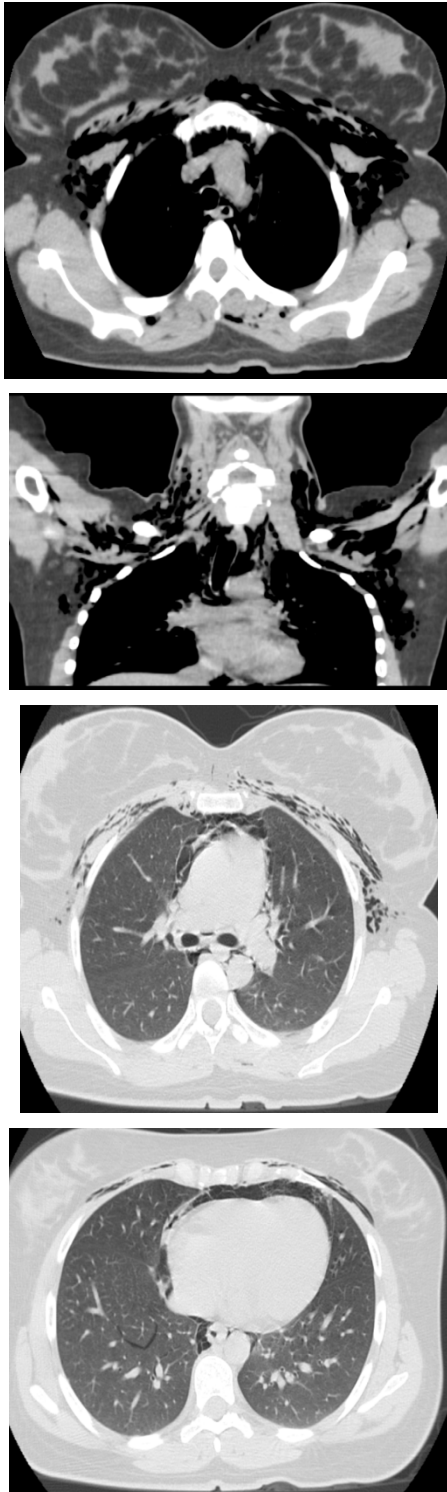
CT scan of the 1st patient in axial section with coronal reconstruction: pneumomediastinum with subcutaneous emphysema, note the air that dissects the pulmonary interstitium (arrow)
